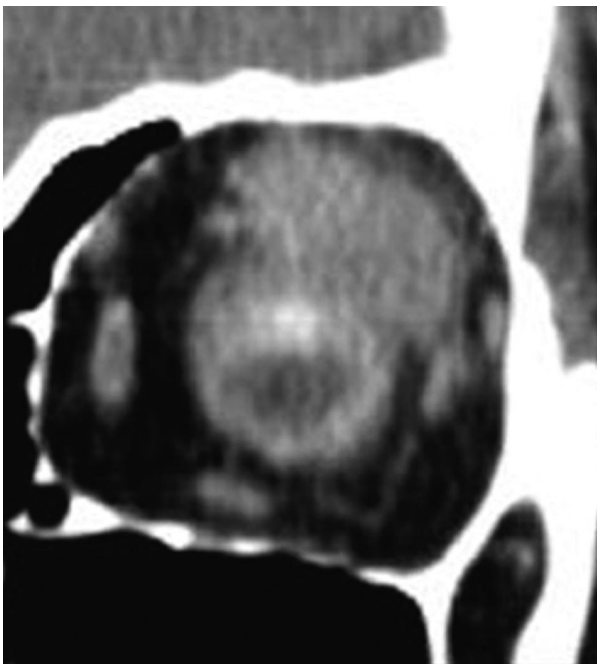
Noncontrast coronal CT scan of left orbit. The mass is inseparable from the superior and lateral rectus muscles.
